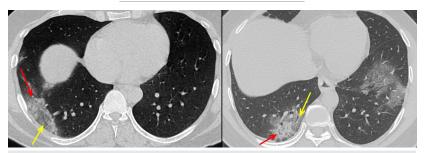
CT scan signs of Covid-19 - ground glass and reversed ground glass haloes. The axial image on the right shows ground glass (red arrow) surrounding an area of consolidation (yellow arrow), while the image on the left, shows the reversed appearance.
